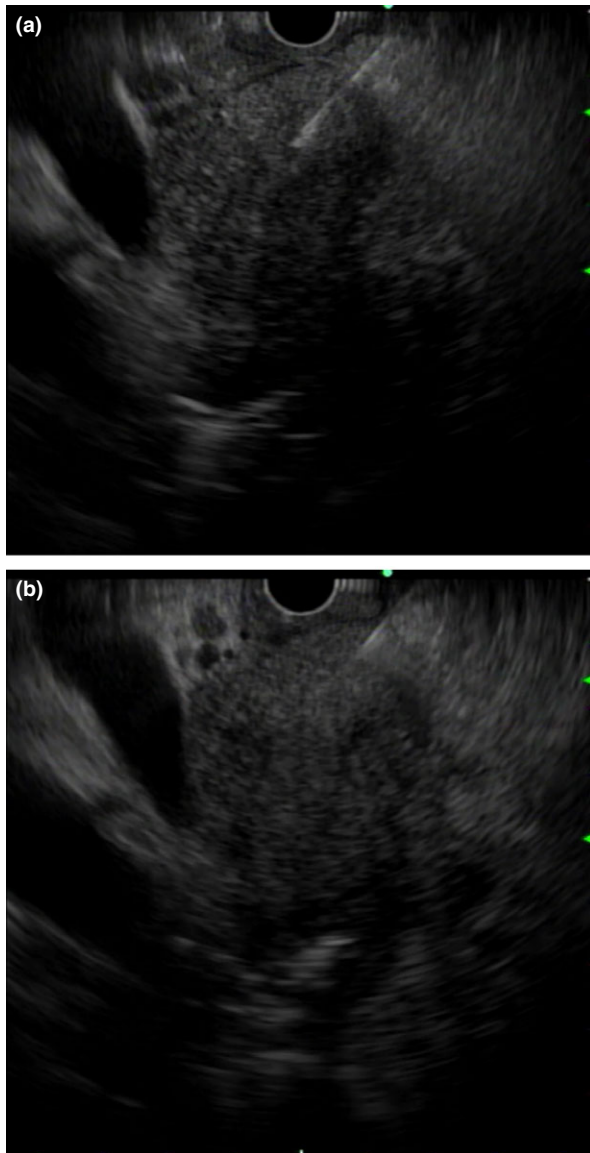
(a) Pancreatic head tumor being aspirated from the duodenal bulb. The entire length of needle is visible in the sonographic field. (b) Slight sideward movement leads to loss of needle tip. The same phenomenon can be seen if the needle is bent, or the scope is torqued. Care must be taken to keep the entire needle length visible in the sonographic view at all times.
